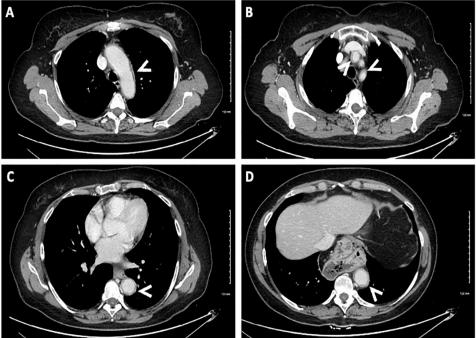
Axial views of computed tomography chest and abdomen demonstrating prominent wall thickening of the aorta (white arrows). (A) aortic arch, (B) left common carotid artery and left subclavian artery, and (C and D) descending aorta which all demonstrate diffuse and circumferential wall thickening without luminal narrowing, suggestive of phase II aortitis.
